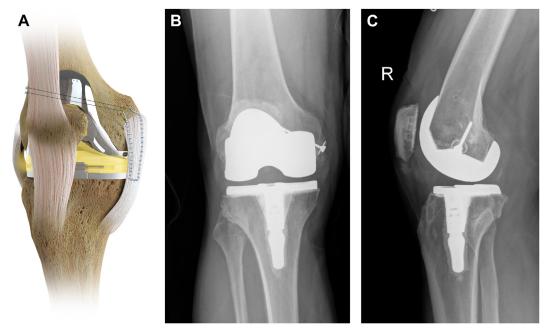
(A) Avulsion of the MCL reattached to the femur with nonabsorbable suture passed through transosseous tunnels and tied over the lateral femoral cortex. (*B*, *C*) AP and lateral radiographs showing avulsion of the MCL reattached to the femur with a screw and spiked washer. The tibial component was a constrained posterior stabilized (CPS) articulation.
